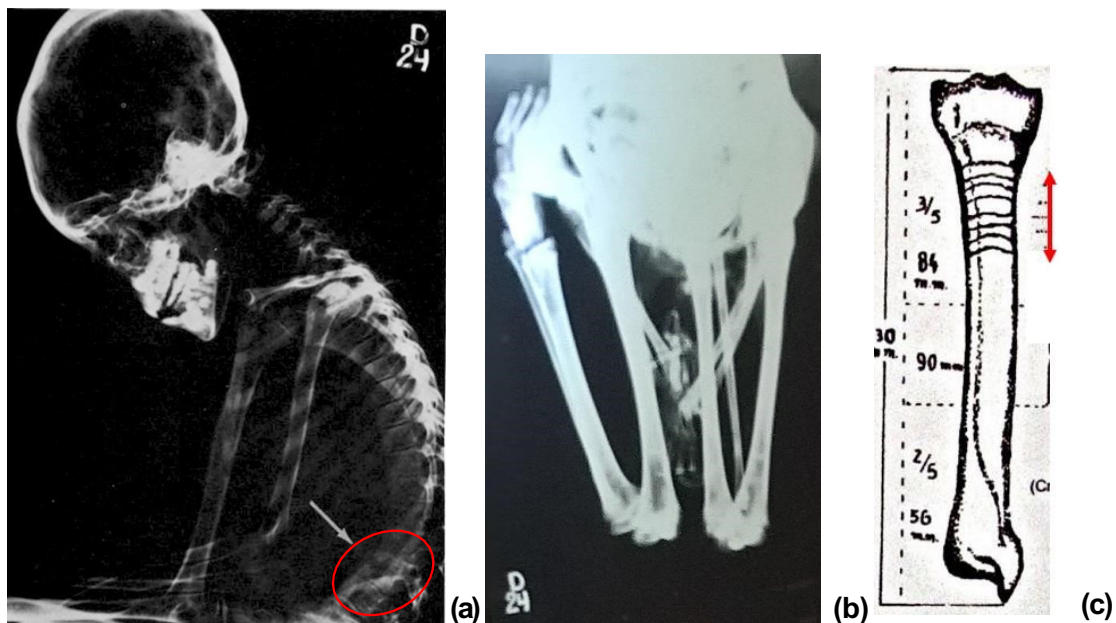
(a) Left lateral X-ray of head and upper body; evidence of TB (Pott’s disease) manifests in changed lumbar spine bone density (arrow). (b) X-ray of lower limbs. Both tibiae exhibit Harris lines (although these are hard to distinguish in the photograph). (c) Sketch of right tibia, Harris lines (indicated) suggesting 7 or 8 instances of growth disruption between ages of 1.5 and 7 years.
